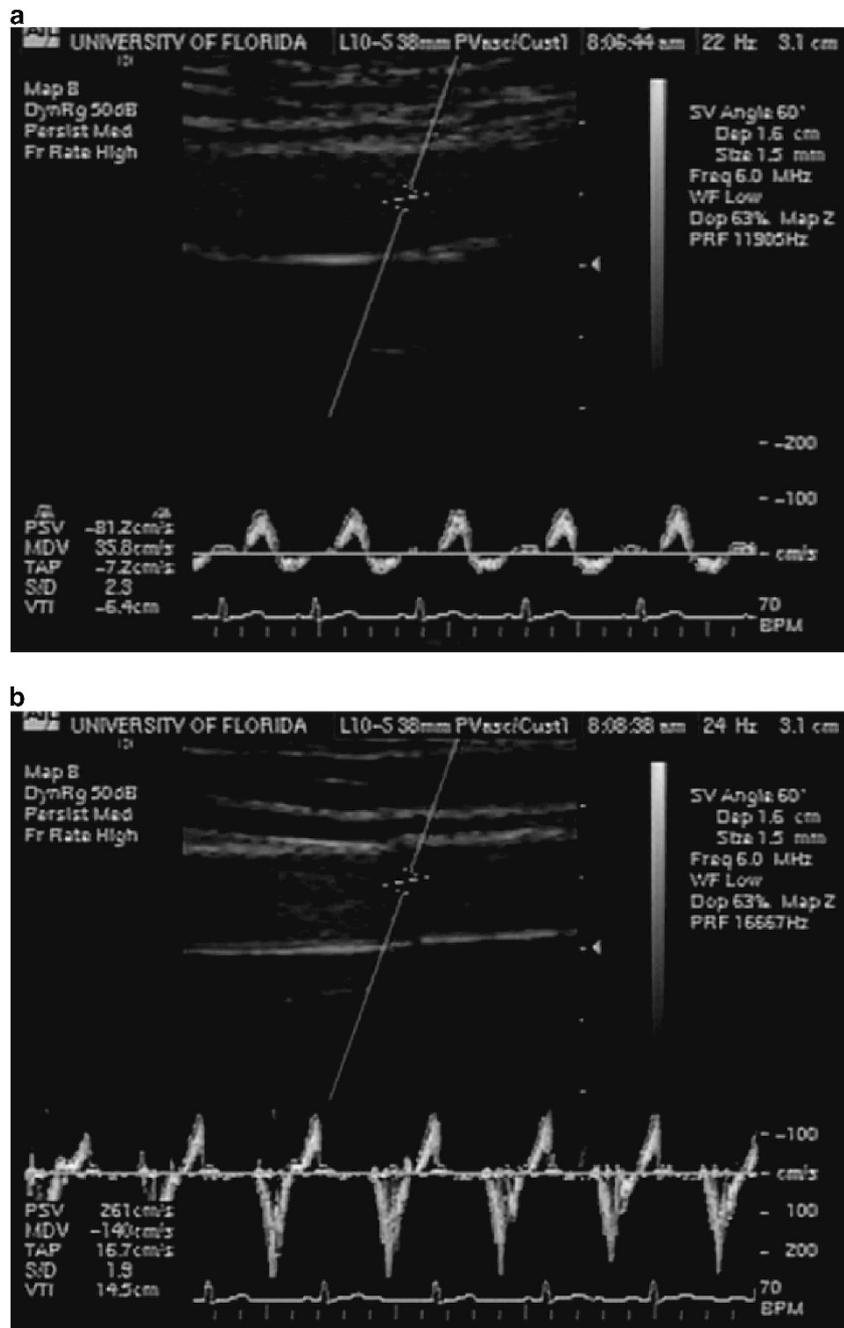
Ultrasound pictures and Doppler spectrum of the femoral artery during Sham (a) and EECP (b).
